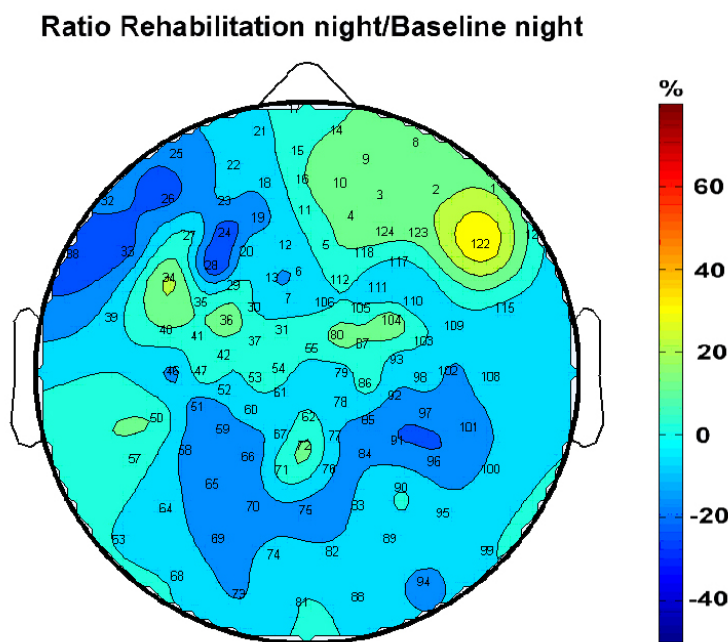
Topographic distribution of the ratio of SWA between the night following rehabilitation (oral motor observation-execution matching and imitation) and a previously recorded baseline night. Electrode number 122 showed the most prominent increase in SWA (~30%). Digitization and co-registration of electrode with magnetic resonance image indicates that electrode 122 projects over the right inferior frontal gyrus (Brodmann's area 44, 45, 47) corresponding to the contralateral homologue of Broca's area.
